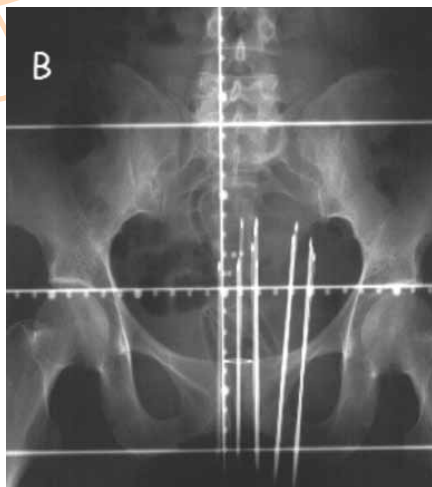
B: A CT image showing the applicator positioned in a patient.
